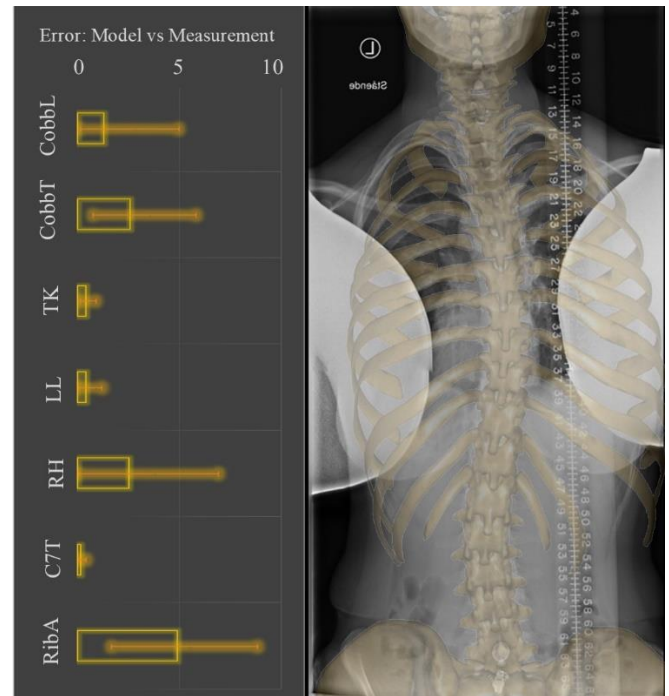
Left:* The average error of the model together with the error bar of the parameters. The angle and distance errors are in degrees and mm, respectively. *Right:* The projection of the transparent model to the radiograph of a patient.
